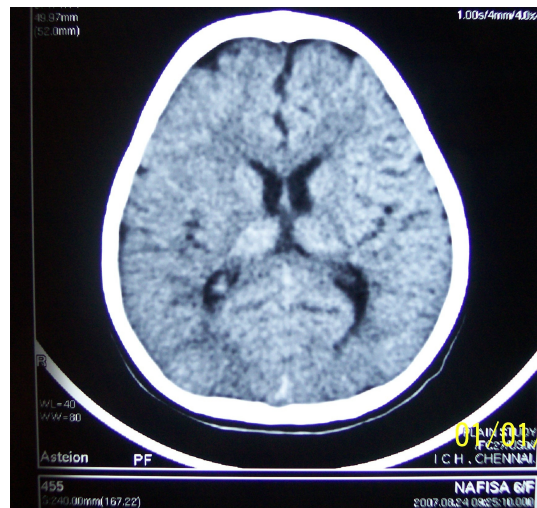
CT picture showing bilateral basal ganglia calcification.
